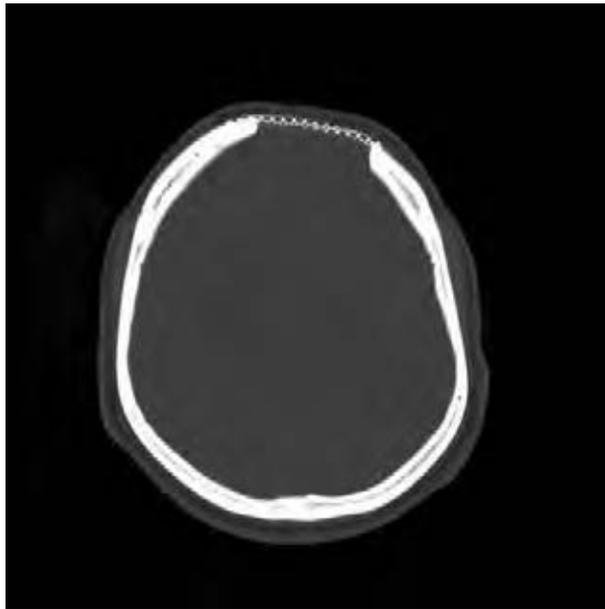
Computed tomography scan, bone window, showing a frontal osteomyelitis -- sagittal view.
